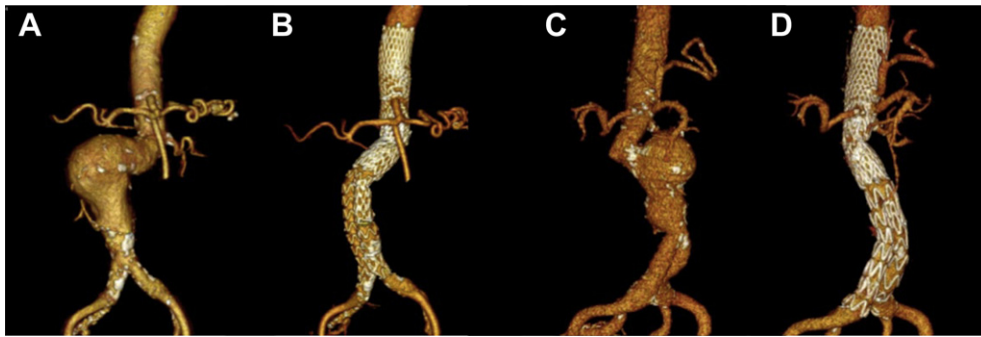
Pre- and postoperative computed tomography (CT) scans showing the challenging angulated proximal aortic neck and the remodeled neck following endovascular repair. In both case 1 (A and B) and case 2 (C and D), the follow-up CT scans show the absence of any endoleak and the patency of all visceral and renal arteries.
